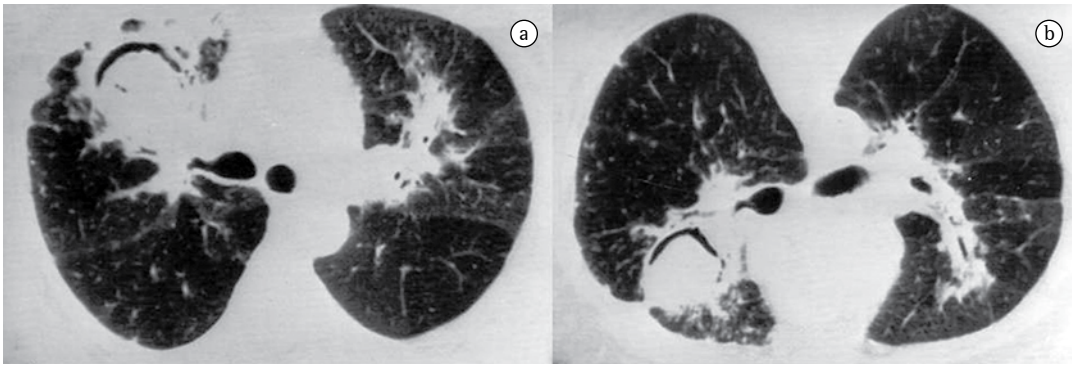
CT scans of the chest obtained after referral: (a) well-defined cavitary lesion in the anterior segment of the right upper lobe; and (b) positional change of the mass within the cavity in the prone position.
